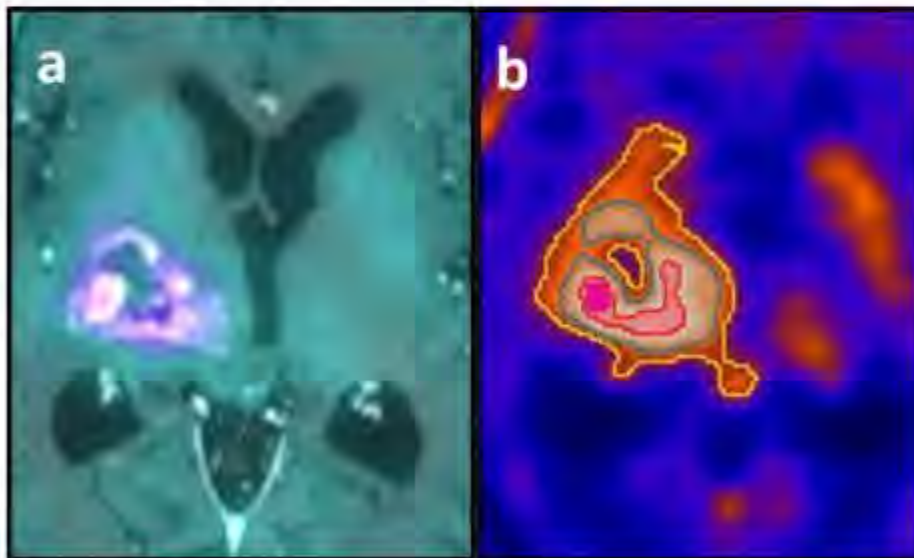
18F-FET PET TBR_{max} volumetric determination in a patient with a right thalamic Glioblastoma. (A.) PET/MR fusion image shows enhanced 18F-FET PET uptake in the area of contrast enhancement on MRI. Static 18F-FET analysis revealed a TBR_{max} of 3.1. (B.) TBR_{max} volumes were determined using cutoffs of TBR 1.6 (yellow outline), 2.0 (blue outline), 2.5 (red outline), and 3.0 (pink outline). The volumes were 42.41 mL, 18.69 mL, 2.91 mL, and 0.53 mL respectively.
